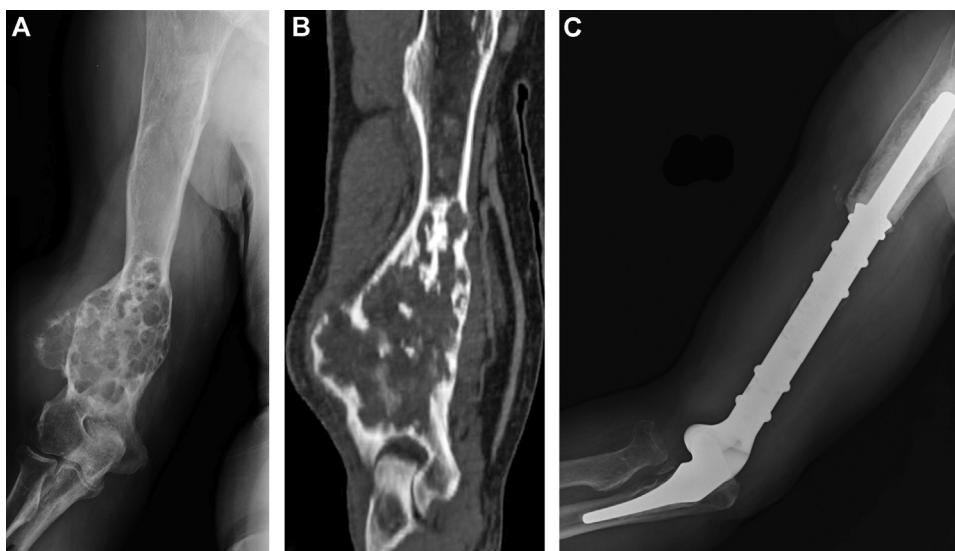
A 63 year-old man with Ollier disease. X-ray (A) and CT (B) show cartilaginous neoplasms involving the distal humerus. Resection and reconstruction with a Mutars modular prosthesis was performed; X-ray (C) shows control at 2 years' follow-up.
